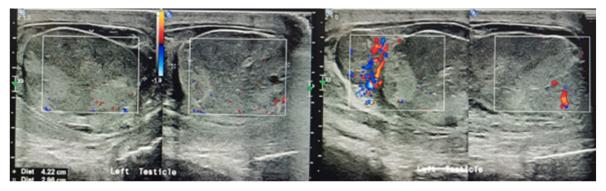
Testicular and Scrotal Ultrasound with Doppler shows scrotal mass and epididimoorchitis of left testicle.
